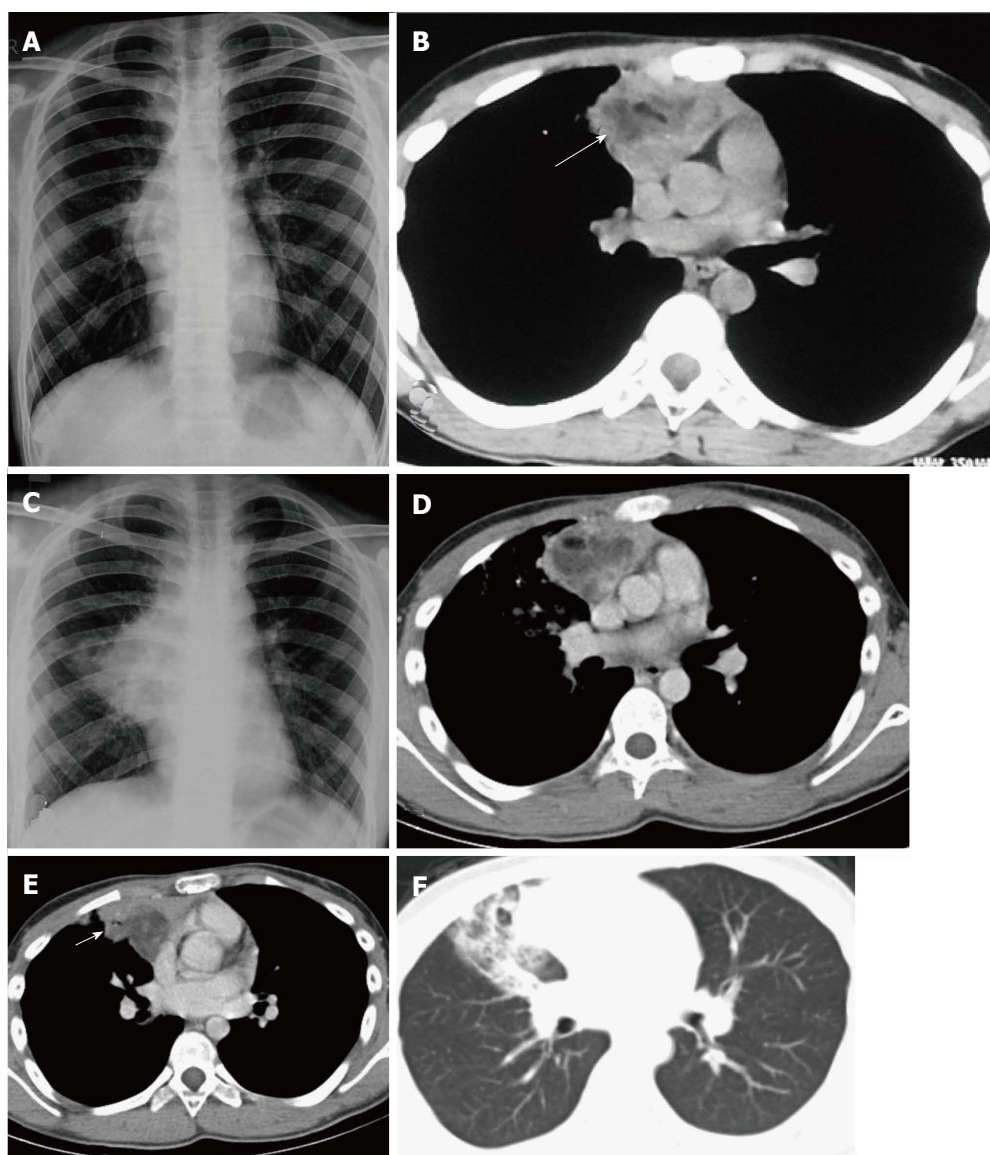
Ruptured anterior mediastinal teratoma in a 14-year-old male. Chest radiograph (A) shows a lobulated soft tissue mass in the right hilar region with obscured inferior margin. CECT axial section (B) shows a heterogenous mass in the anterior mediastinum with soft tissue, fluid and fat suggestive of anterior mediastinal teratoma. The patient refused surgery and presented 5 mo later, with complaint of cough and expectoration of foul smelling material. Chest radiograph (C) shows a large right hilar mass with irregular margins and patchy consolidation in the adjacent right mid zone. CECT (D) also demonstrates the increase in the size of the mass and irregular margins. There is evidence of small air foci (arrow in E) within this mass with adjacent consolidation suggestive of rupture into the tracheobronchial tree. Axial CT lung window (F) shows the adjacent ground glass and consolidation in the right middle lobe.
